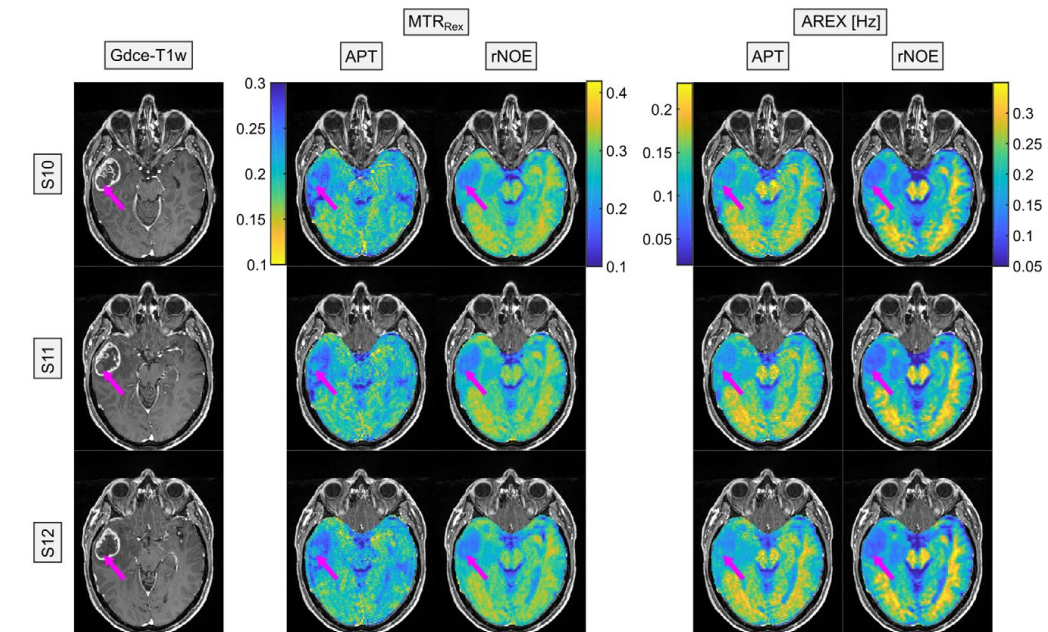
Relaxation-compensated CEST-MRI ($B_1 = 0.7 \mu\text{T}$, slices 10-12 of 16) of a patient with newly diagnosed glioblastoma (WHO grade IV) examined at 3 T. The tumor volume can be seen in the co-registered gadolinium contrast-enhanced T_1 -weighted (Gdce- T_1w) images. The pink arrows indicate a hyperintense region, which most likely corresponds to a blood clot within the tumor
